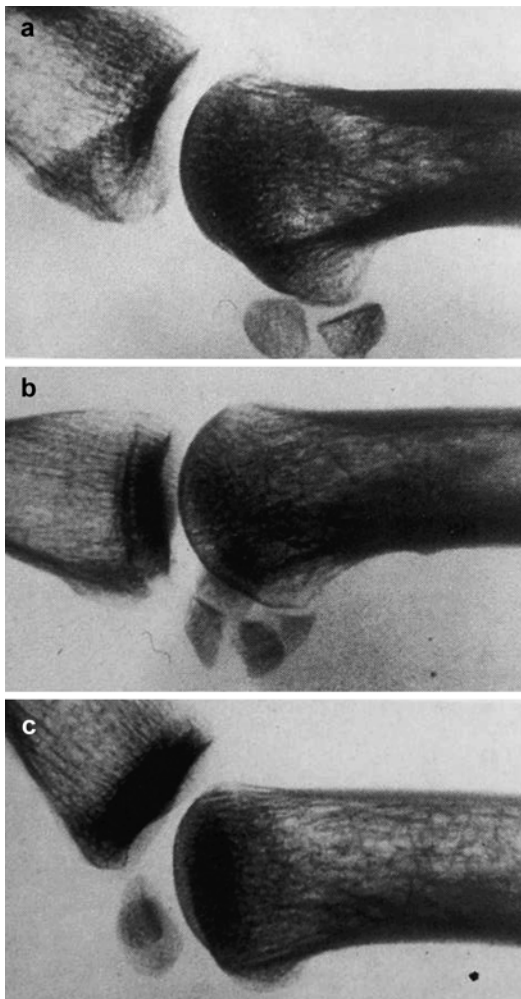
How a lateral radiograph assists in determining the location of the volar plate (VP) tear. (a) Distal lesion: The VP has torn off from the proximal phalanx thus an extension view distances the sesamoids from the base of the proximal phalanx. (b) Both radial and ulnar sesamoids are fractured. (c) Proximal lesion: the sesamoids move with the proximal phalanx; the VP need not be attached here for it is flimsy (Taken with permission from Stener [54])
